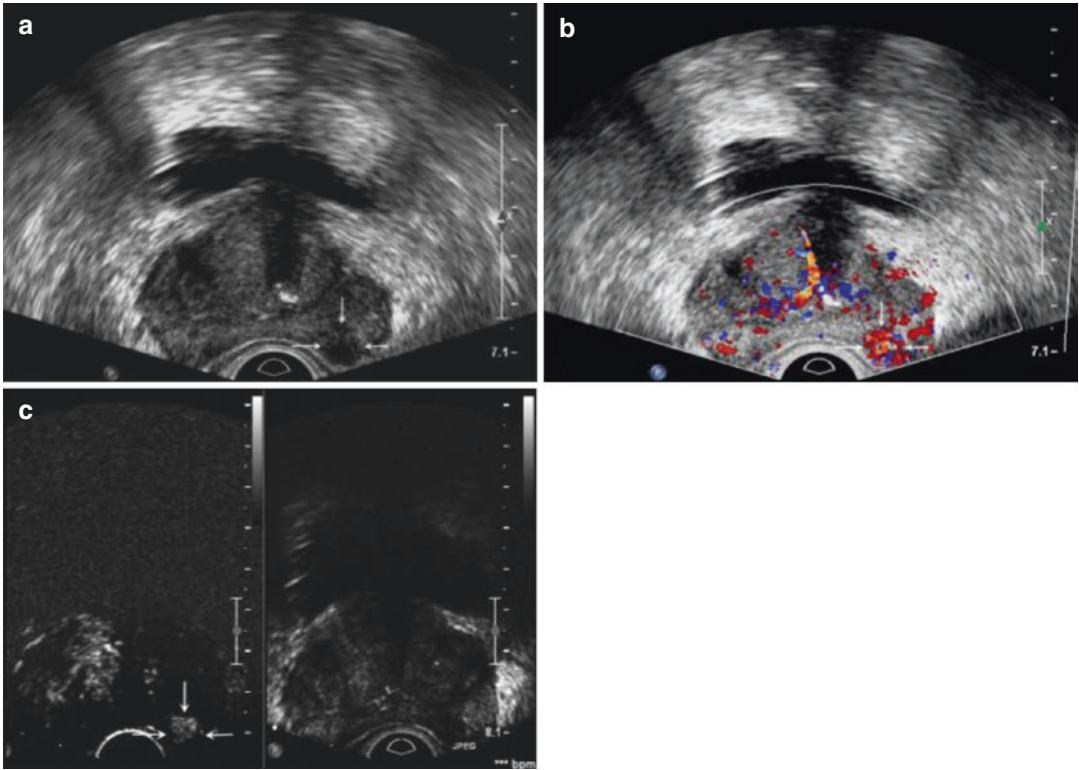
An 84-year-old patient with prostate-specific antigen (PSA) of 8.8 ng/mL. (a) The image with gray scale demonstrates a round hypoechoic area in the left median region (*arrows*). (b) The color Doppler image demonstrates an increasing vascular flow in the region (*arrows*). (c) The CEUS image evidences a significant enhancement in the lesion, 20 s after the administration of the contrast medium. The pathologic exam evidenced BPH. The guided biopsy documented PCa Gleason score 3+3
